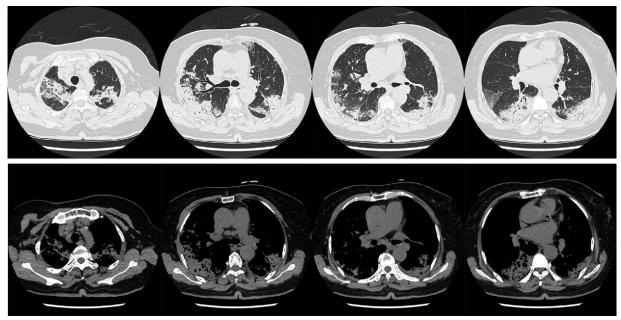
Computed tomography (CT) images after antibiotic treatment. After 7 days treatment of moxifloxacin, chest CT was performed again, and indicated progression of the lesion.
